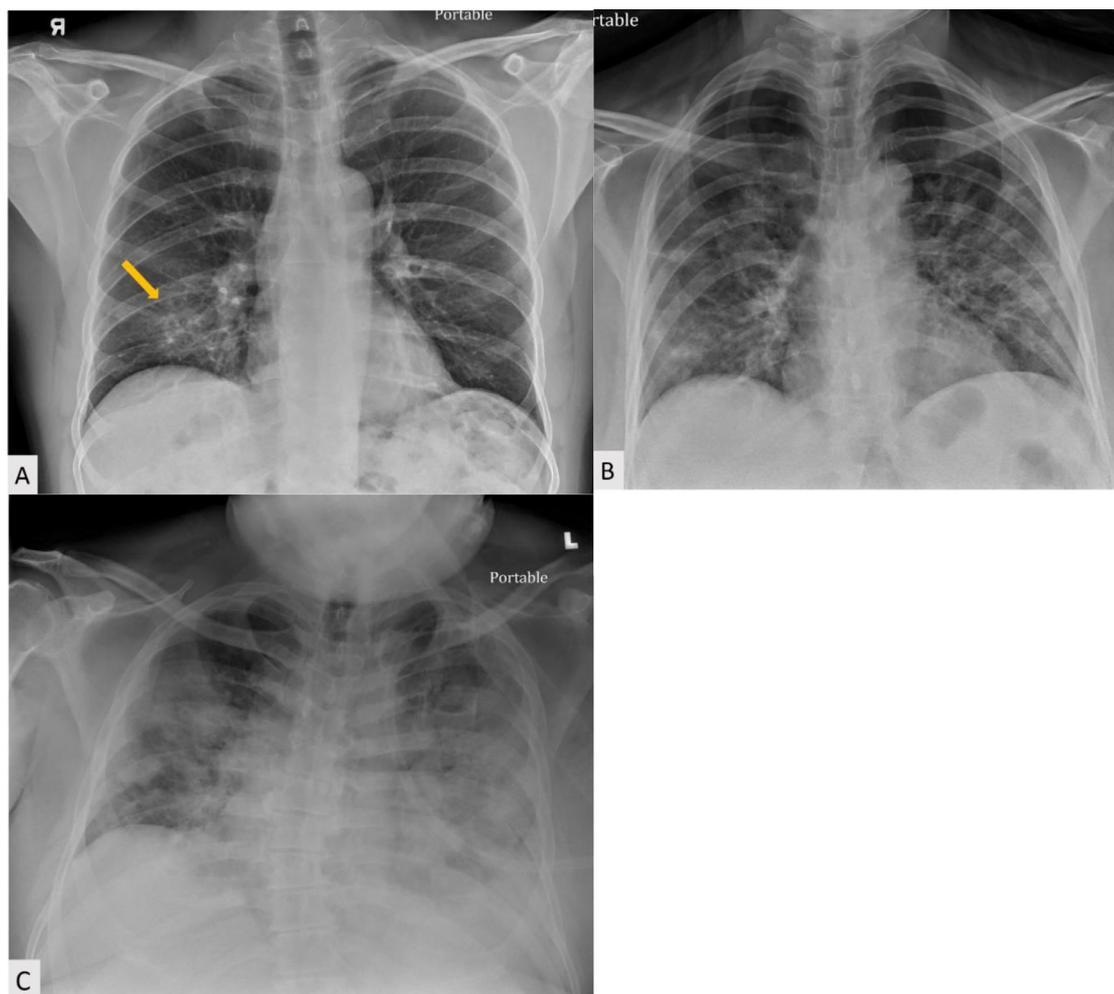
(A) Frontal chest radiograph in a patient with mild COVID-19 demonstrates hazy, patchy opacity with a rounded morphology limited to the right lower lung zone (arrow); (B) Frontal chest radiograph demonstrates moderate acute COVID-19 with bilateral patchy pulmonary opacities with a peripheral and lower lung distribution; (C) Frontal chest radiograph demonstrates severe bilateral diffuse pulmonary consolidation, similar to findings in diffuse acute lung injury of any etiology.
